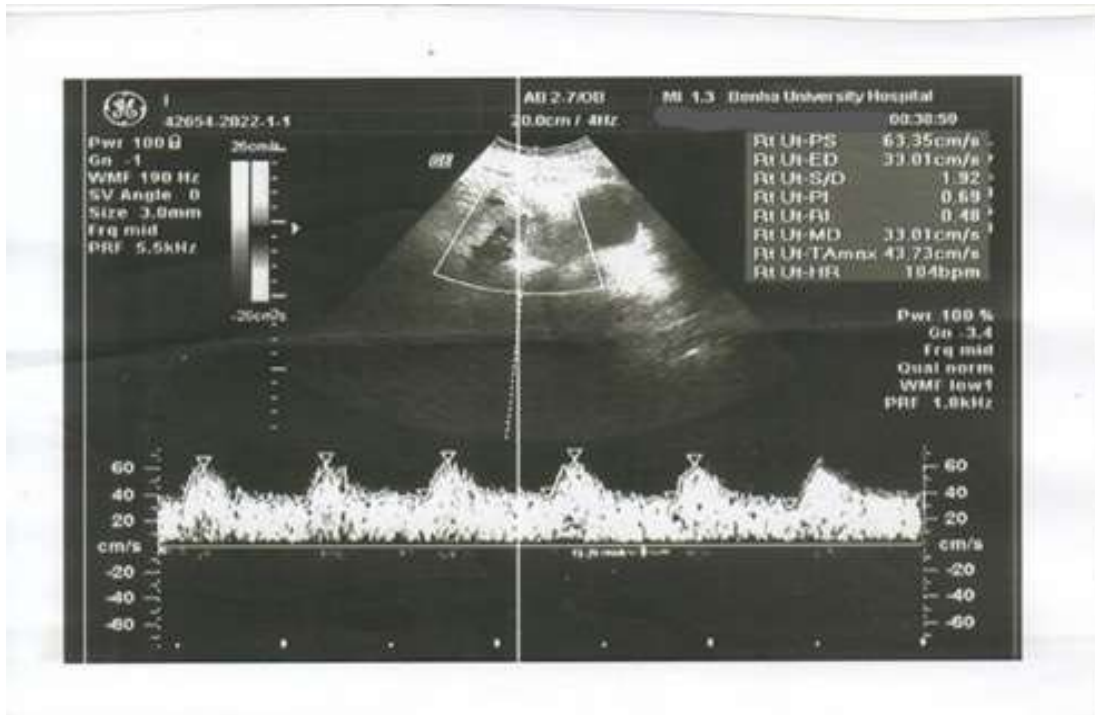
showed right uterine artery Doppler velocimetry parameters measurement at 22 weeks gestational age.
